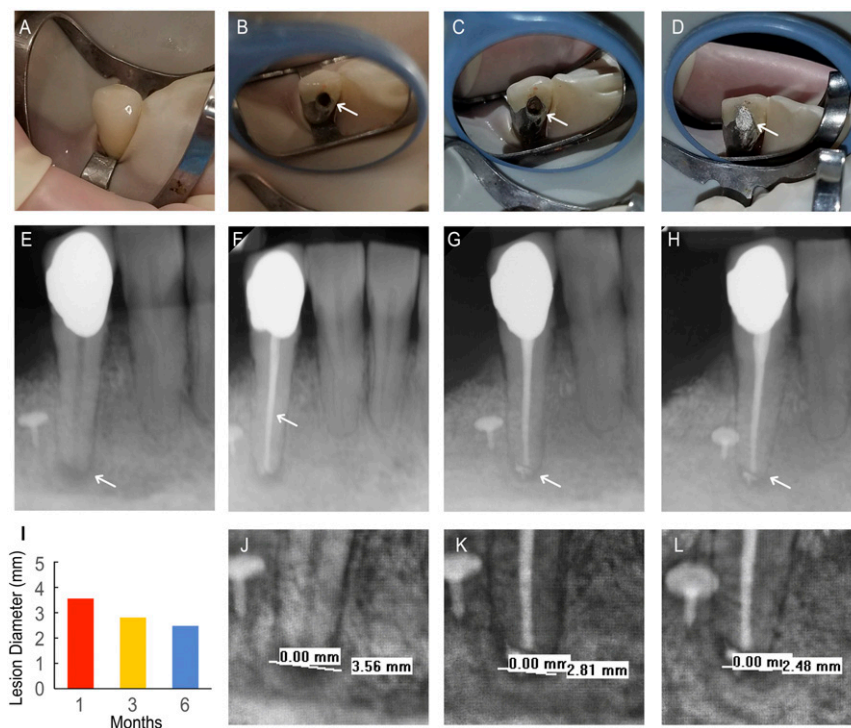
NDGP-treated patient 1 (ND1). (A) Pretreatment clinical image of tooth 27 taken after rubber dam placement. (B) Clinical image of access cavity (white arrow) before obturation. (C) Clinical image of completed obturation visible through access cavity (white arrow). (D) Clinical image of coronal restoration sealing access cavity (white arrow). (E) Pretreatment radiograph with periapical lesion (white arrow). (F) Completed obturation with unmodified GP apical seal, NDGP backfill, and unmodified GP coronal seal. (G) Three-month follow-up radiograph with healing periapical lesion (white arrow). (H) Six-month follow-up radiograph with healing periapical lesion. (I) Lesion diameter at pretreatment, 3-mo, and 6-mo follow-up appointments. (J) A 3.56-mm lesion was visible on pretreatment radiograph. (K) A 2.81-mm lesion diameter was visible on the 3-mo follow-up appointment. (L) A 2.48-mm lesion diameter was visible on the 6-mo follow-up appointment.
